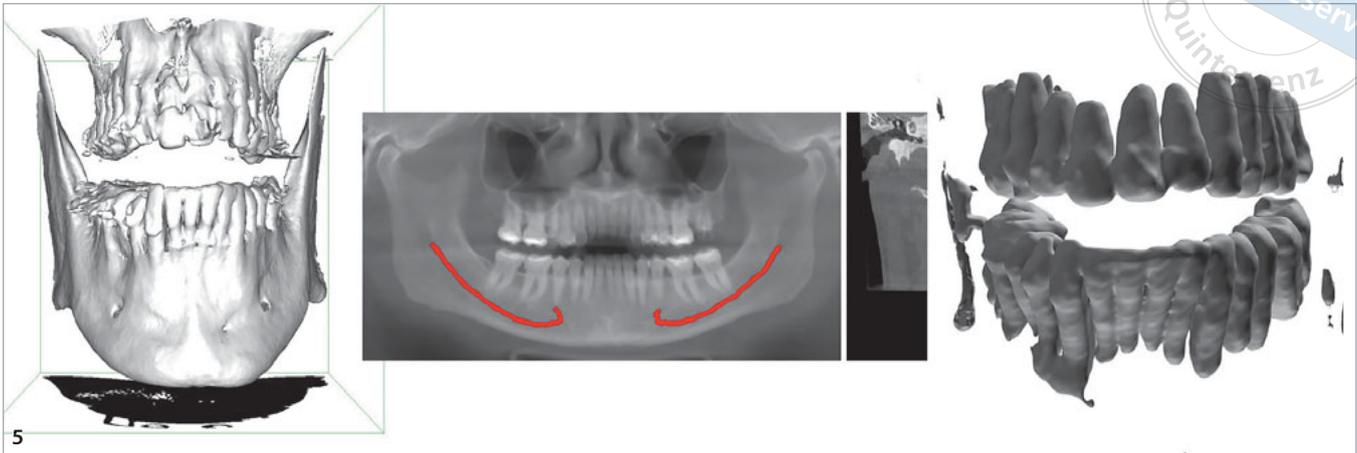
Automatic structure segmentation, annotation, and data conversion into STL files using AI technology. When the CBCT scan is imported to the software, the AI will instantly segment the tooth surface and bone structure, and eliminate the artifacts. The inferior alveolar nerves (red line) can be identified without human interpretation.
